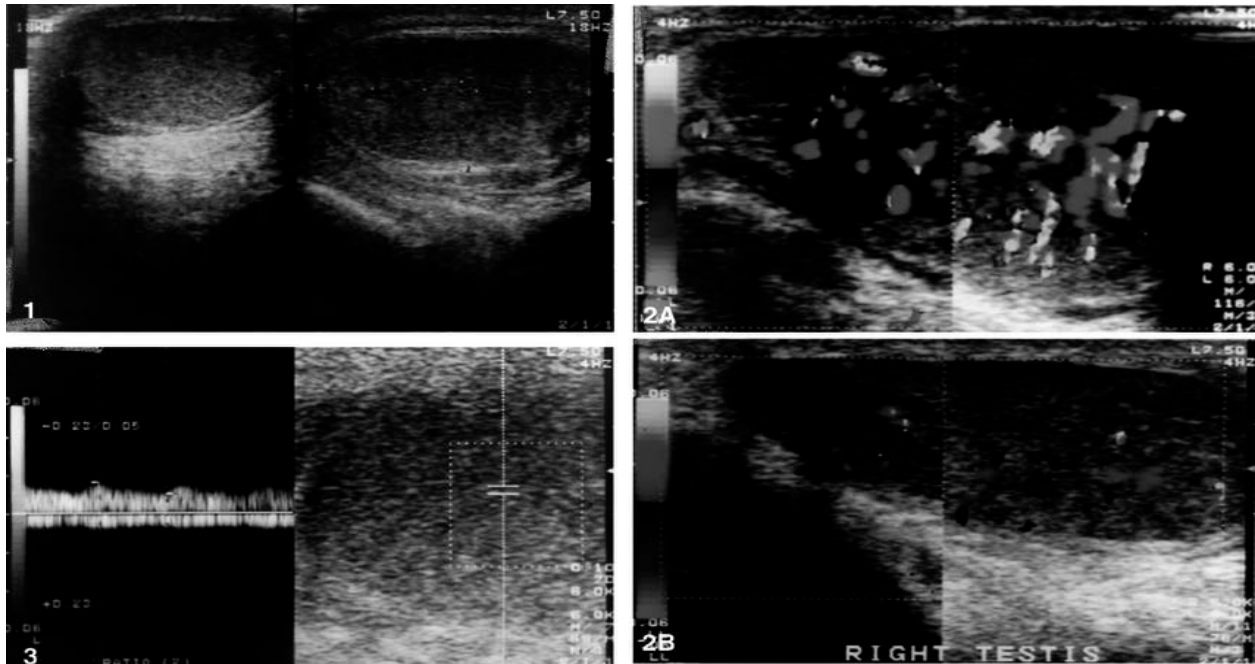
showing sonogram of longitudinal testicular enlargement and in bilateral orchitis case.
